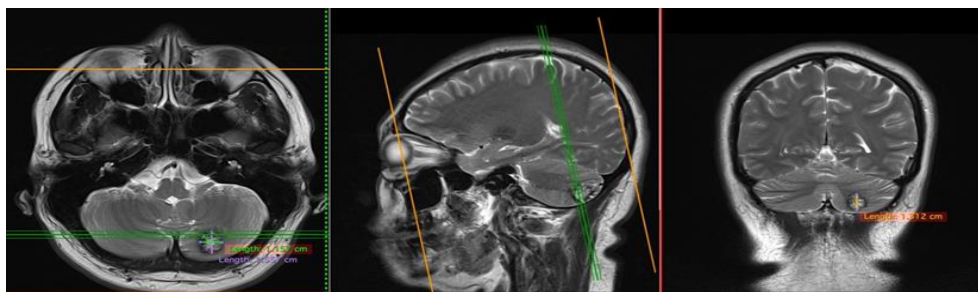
Head MRI with contrast shows a venous angioma in the hemisphere of the left cerebellum with a size of $\pm 1.65 \times 1.3 \times 1.5$ cm with acute intracerebellar bleeding
